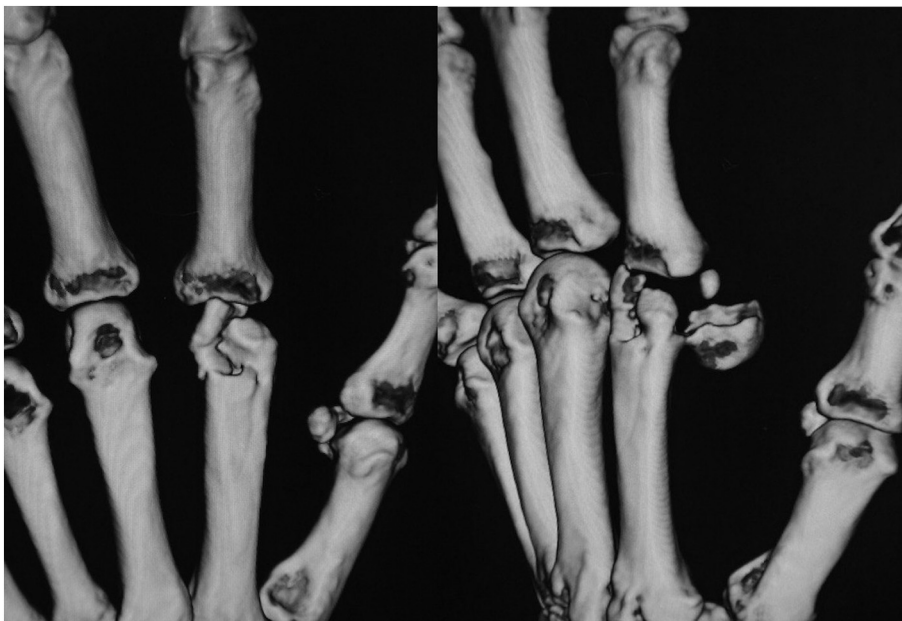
Three-dimensional computed tomography reconstruction after closed reduction.
